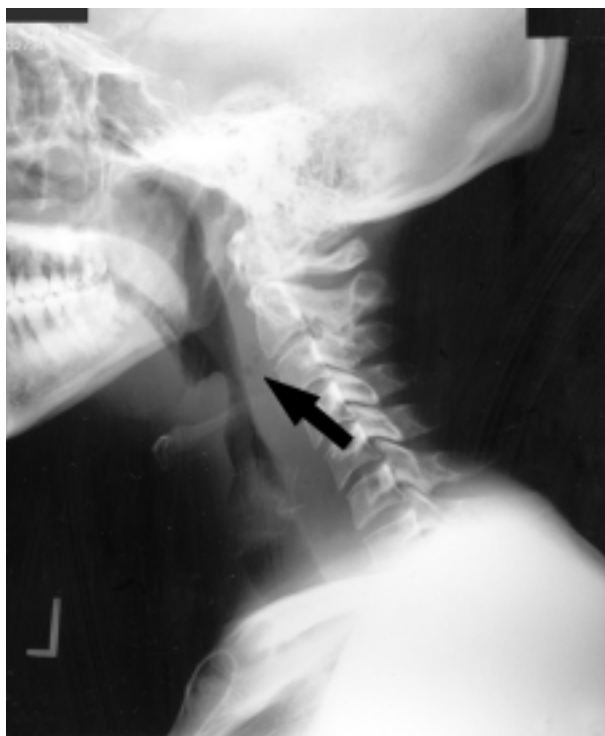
Soft-tissue radiograph of patient 1 showing the presence of gas (arrow).
